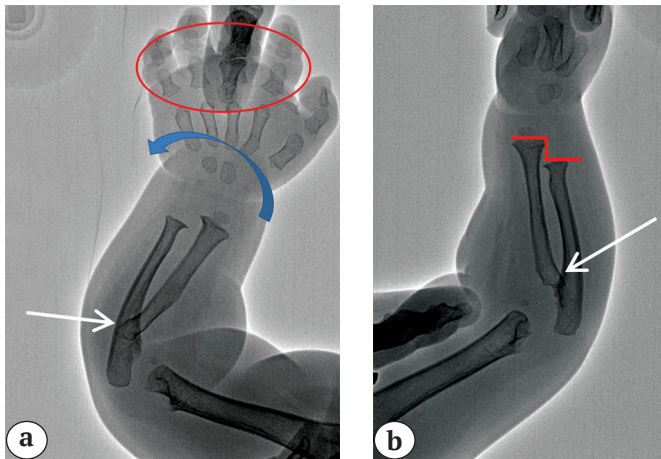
X-rays of the forearm and hand of patient 2 (a – anteroposterior, b – lateral view): relative shortening of the ulna (red line); dorsal subluxation of the radial head (white arrows); ulnar deviation of the hand (blue arrow); short and wide basal and middle phalanges of the fingers (red circle).
